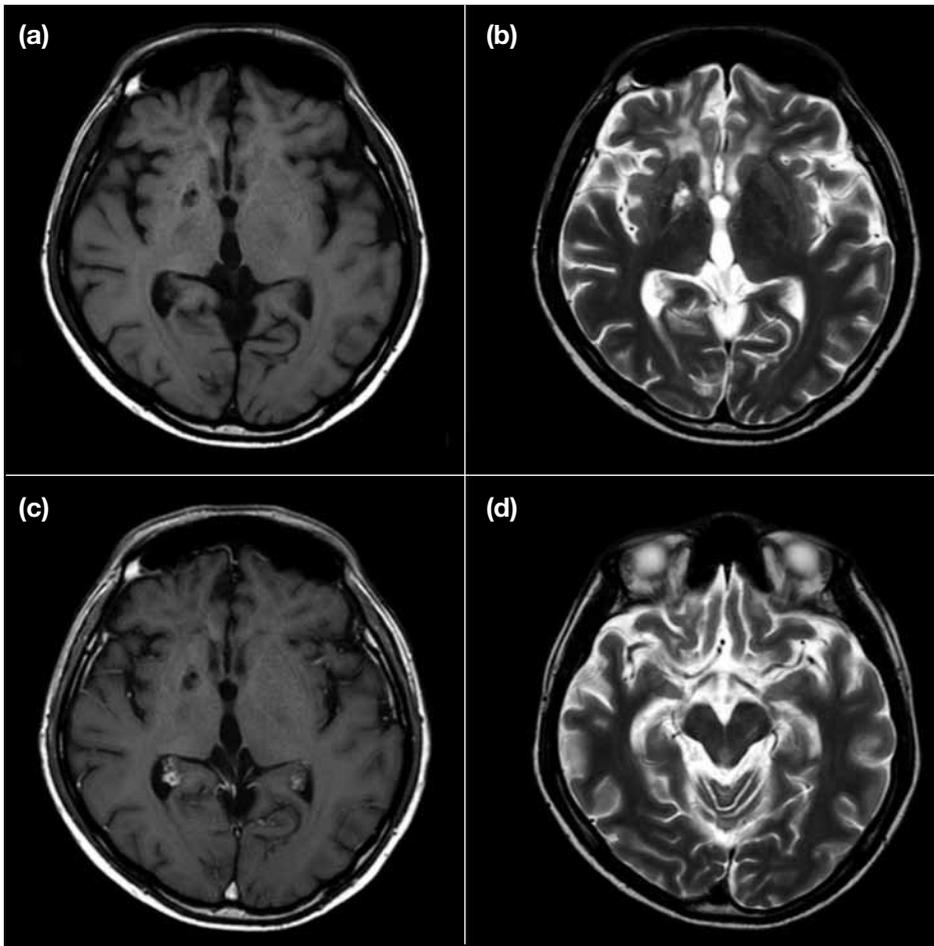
Case 2. 19-year-old male patient. Post-treatment magnetic resonance imaging (MRI) demonstrated cystic changes in the right globus pallidus without evidence of tumour recurrence. (a) Axial T1-weighted; (b) T2-weighted; and (c) post-contrast T1-weighted MR images. (d) Axial T2-weighted MR image at the midbrain level showed minimal right Wallerian degeneration.
